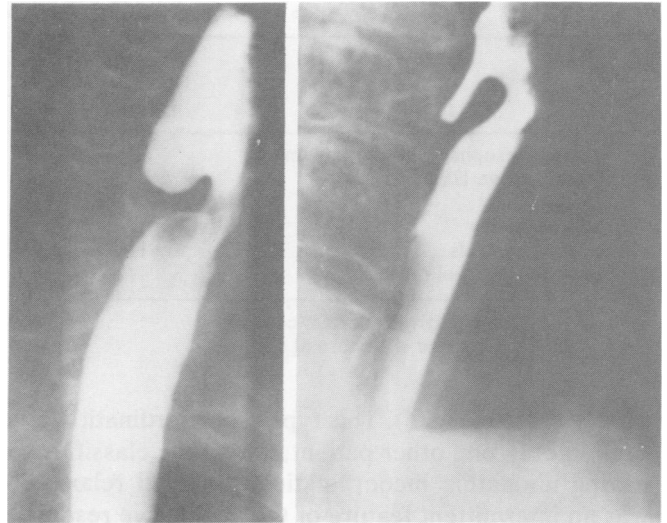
Roentgenographic appearance of cervical esophagus in two patients with hypertensive UES. Note posterior indentation of barium-filled esophagus by cricopharyngeus muscle.
